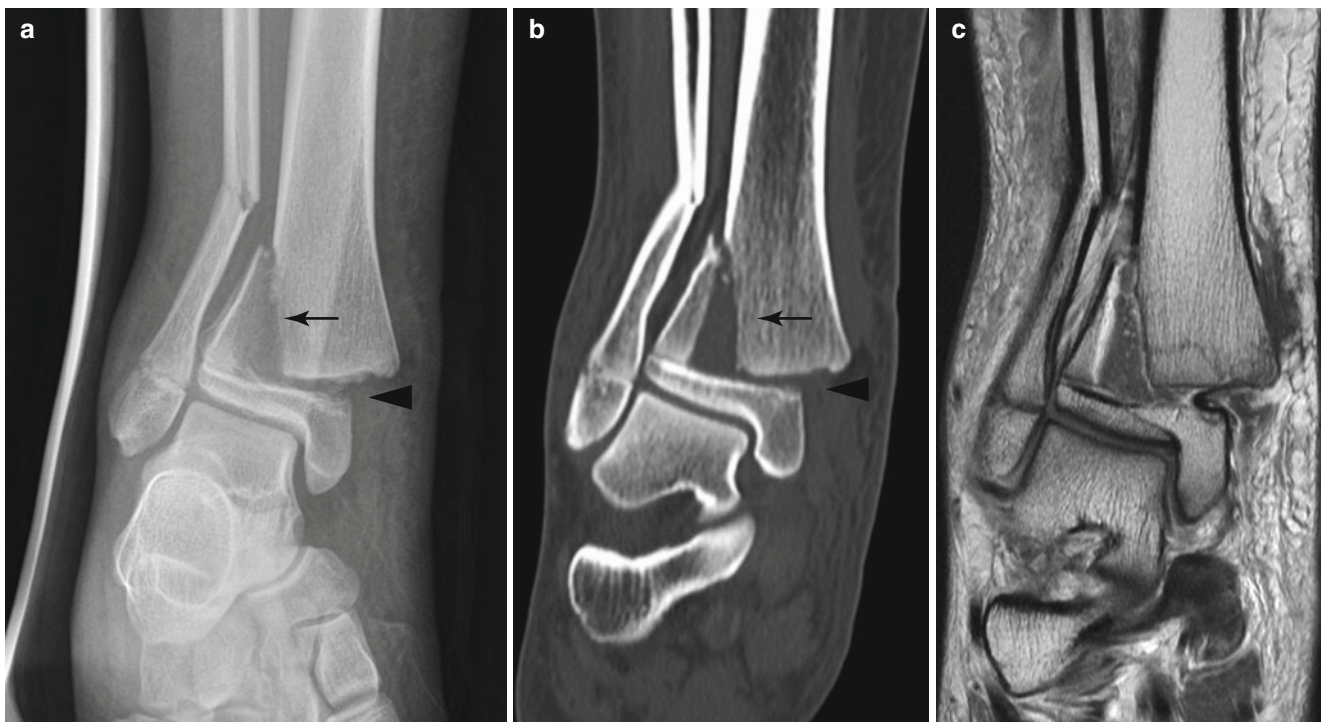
Salter-Harris type 2 fracture in an 11-year-old girl who had sustained a fall from height and injured her right ankle. (a, b) Anteroposterior radiograph and coronal CT image of the right ankle show a displaced metaphyseal fracture (arrow) and an extension into the physis (arrowhead) with a fibular shaft fracture by an abduction injury. (c) Proton density coronal MR image also demonstrates Salter-Harris type 2 fracture involving right ankle with soft tissue swelling and effusion
